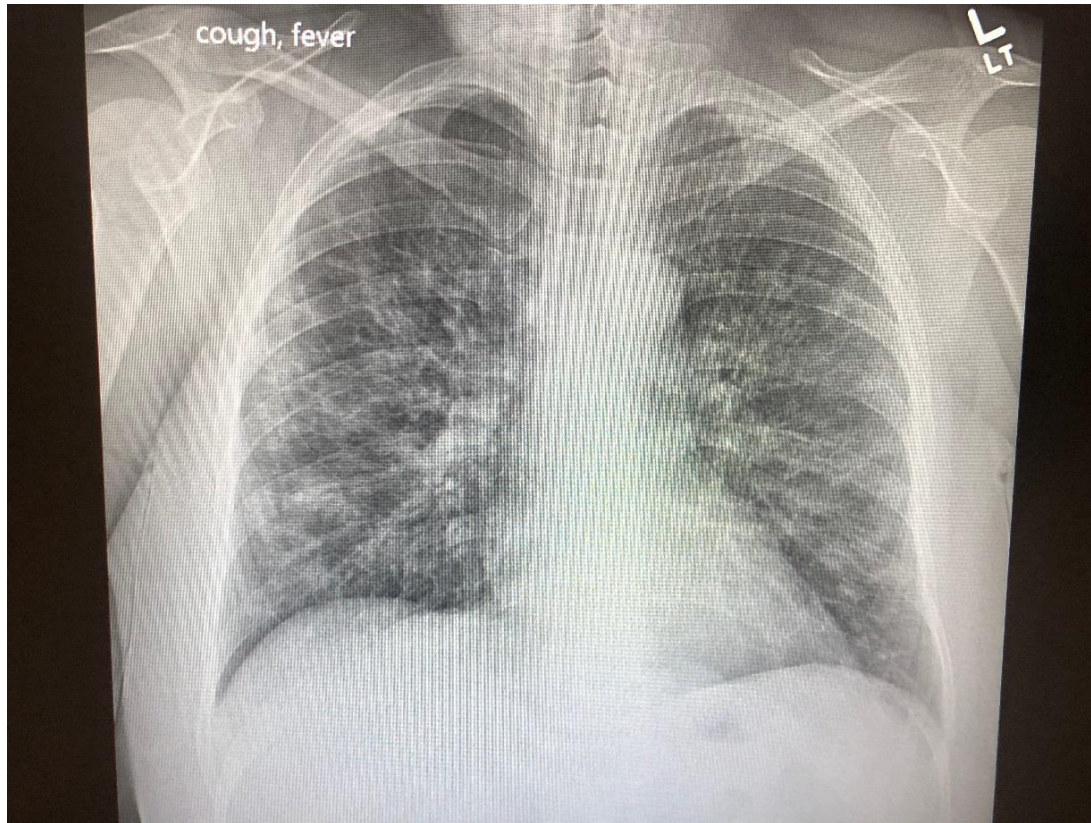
Day #11, chest x-ray with new onset bilateral pneumonia
